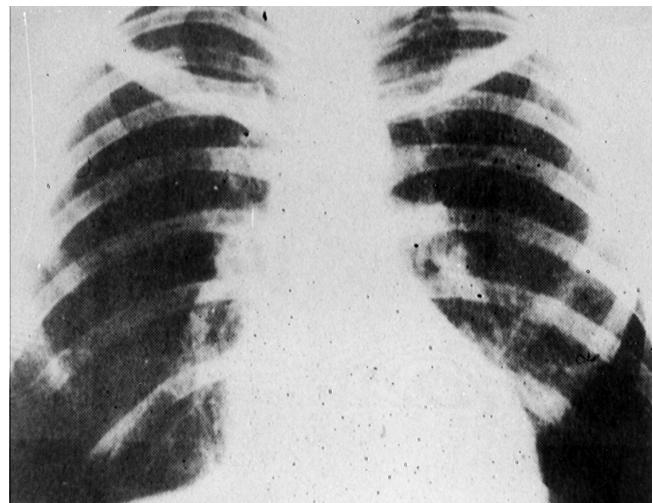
X-ray examination of the heart of Mr E. Z. when aged 29 years.
